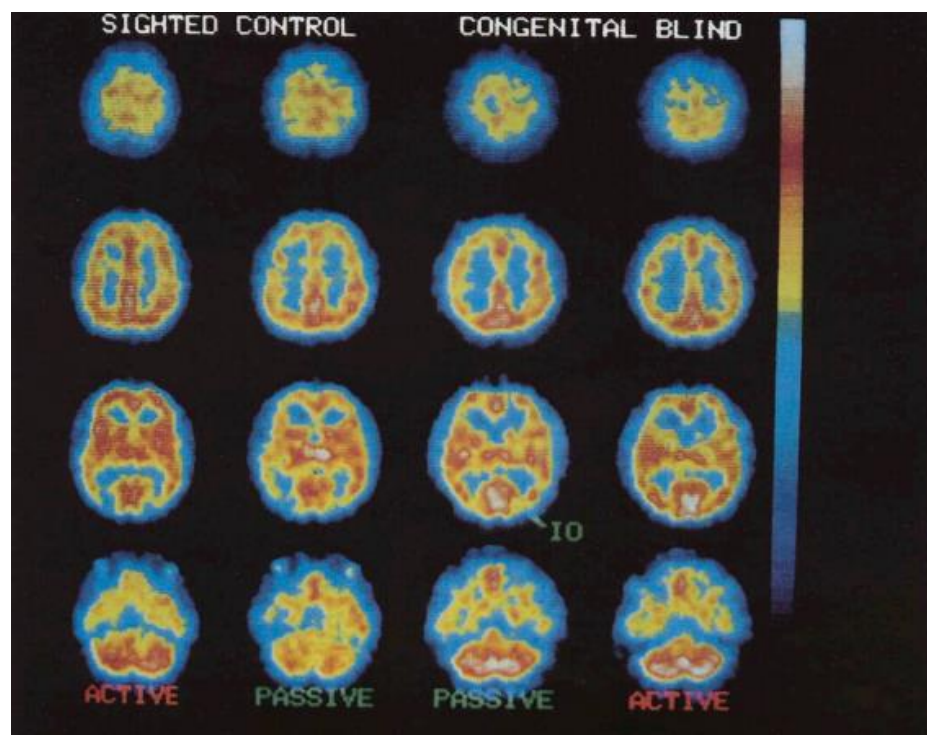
Increased regional cerebral blood flow in inferior occipital cortex and cerebellum of early blind and sighted control persons, measured by Brain-SPECT. To the left: right hemisphere. To the right: left hemisphere. Inferiorly: postcentral part of the brain and cerebellum. Superiorly: Precentral part of the brain. Adapted from Uhl *et al*, 1993.
